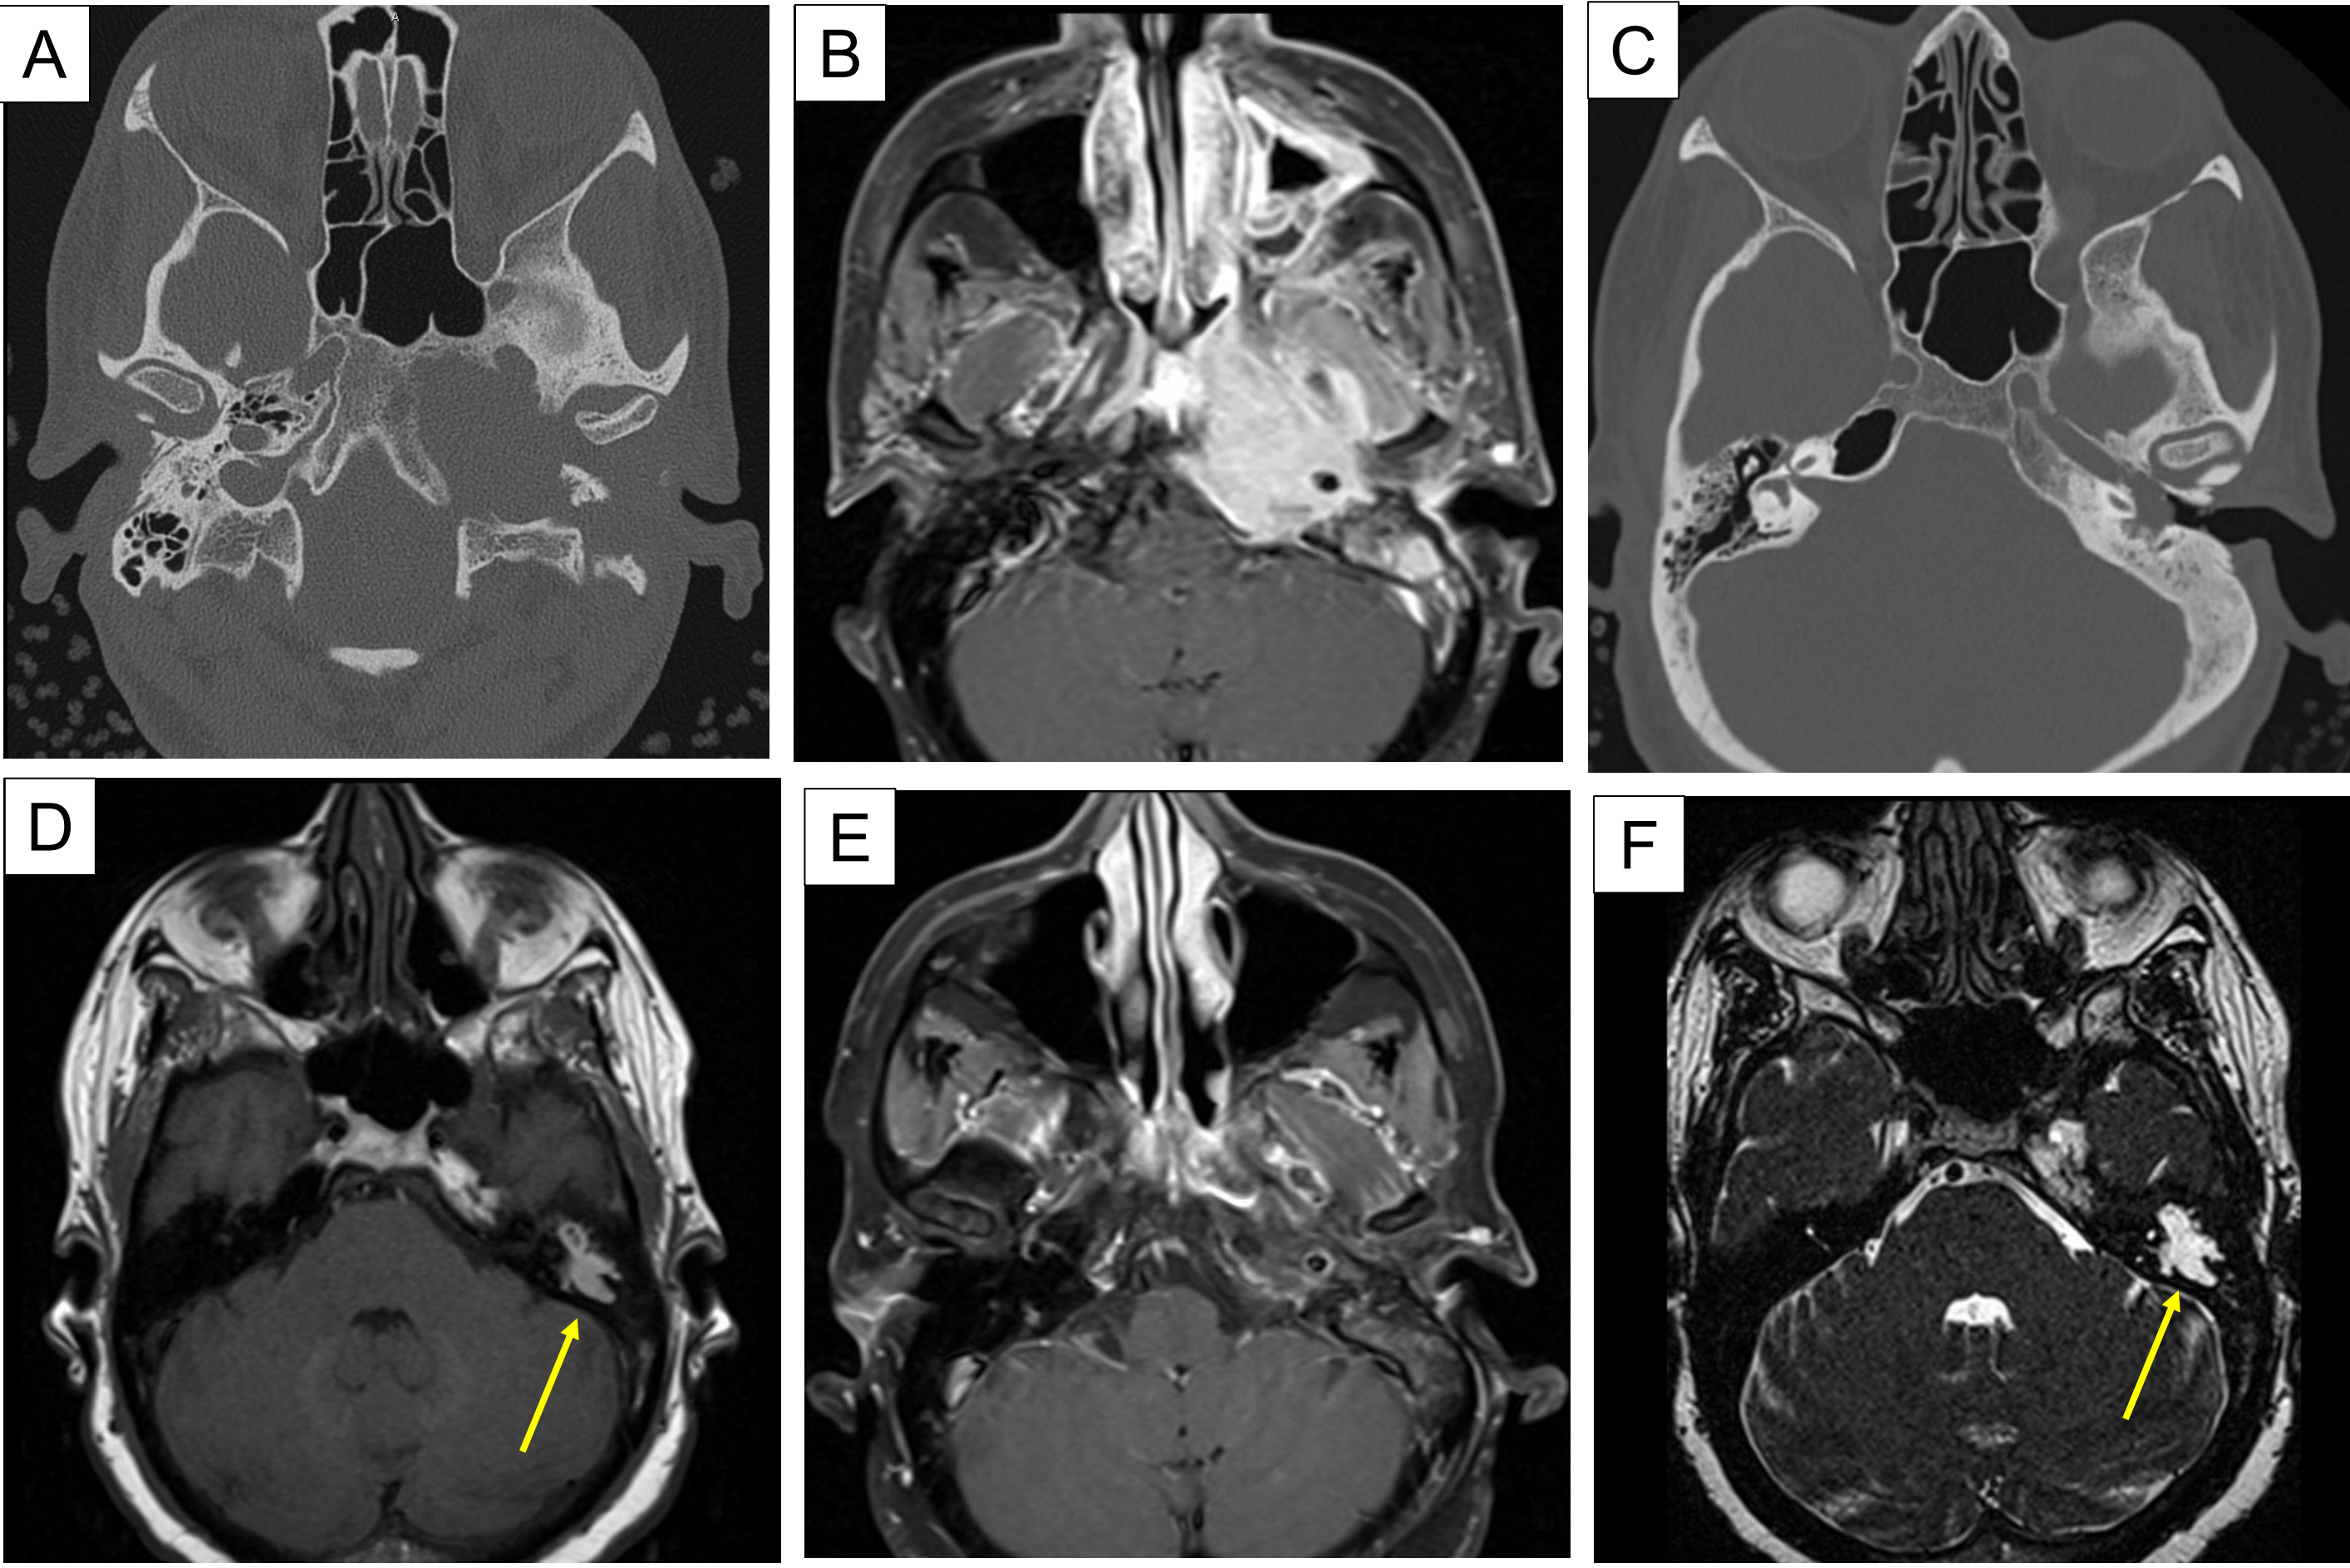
Lytic skull base lesion with remineralization of bone over time. A) Axial CT scan without contrast, March 2016. Note the erosion of the petrous carotid canal and clivus. There is also erosion into the left foramen ovale, mastoid (especially along the course of the tympanic facial nerve), and basal turn of the cochlea. B) Axial MRI IAC, T1 with contrast, November 2015. Note the large area of enhancement along the left nasopharynx and parapharyngeal space. This surrounds the carotid artery and involves the pterygoid musculature. C) Axial CT scan without contrast November 2024. Note the reconstitution of bone along the petrous carotid canal, basal turn of the cochlea, and glenoid fossa. E) Axial MRI IAC, T1 without contrast. Note the hyperintense signal in the mastoid and middle ear space (arrow). D) Axial MRI IAC, T1 with contrast, November 2024. Note the marked improvement of enhancement. Not pictured here is persistent enhancement in the region of the left foramen ovale. F) Axial MRI IAC, T2. Note the hyperintense signal in the mastoid and middle ear space (arrow).
